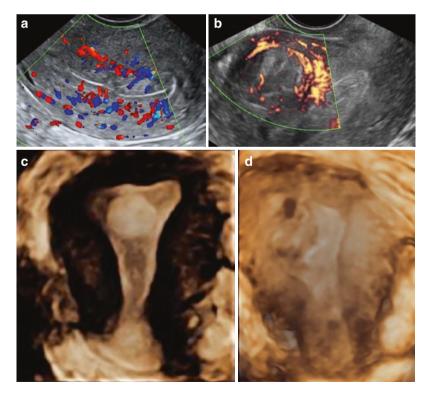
(a) Colour Doppler image of the endometrium showing polyp with single feeding vessel, (b) power Doppler image of the uterus showing anterior myometrial fibroid with typical peripheral vascularity, (c) 3D ultrasound rendered image of polyp, (d) 3D ultrasound image of the submucous fibroid
